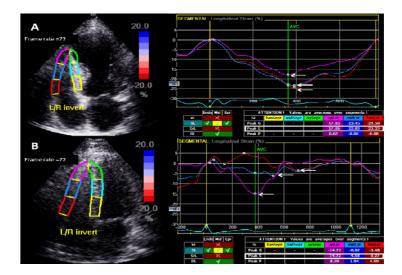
Right ventricle strain was calculated automatically by tracing the endocardial margin of the right ventricle in an apical 4-chamber view. The apical, middle and basal segments of RV peak systolic strains were highlighted (arrow) and the average of the regional strains was recorded. (A) An example of preserved right ventricle strain. (B) An example of impaired right ventricle strain
